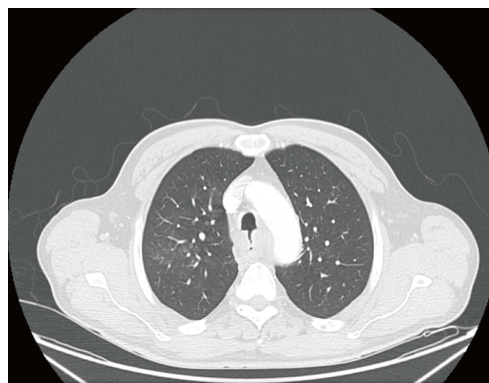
Contrasted chest computed tomography imaging showing tracheoesophageal fistula in a 60-year-old male patient.
